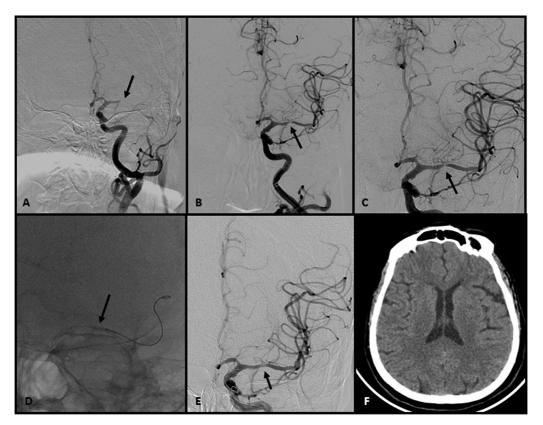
A 73 years old female who is a known hypertensive presented with right hemiplegia and aphasia for 6.5 hours with National Institutes of Health Stroke Scale (NIHSS) of 20. Imaging showed left M1 middle cerebral artery (MCA) occlusion with diffusion-weighted imaging (DWI) Alberta Stroke Program Early Computed Tomography Score (ASPECTS) of 8. (A) (arrow) Left M1 MCA occlusion for which underwent mechanical thrombectomy using modified Solumbra technique achieving modified Thrombolysis in Cerebral Infarction (mTICI) 3 recanalization with significant residual stenosis (90%) (arrow, B). Intra-arterial tirofiban was administered using a microcatheter to prevent reocclusion (arrow, C). Because of significant residual stenosis due to underlying intracranial atherosclerotic disease (ICAD), submaximal angioplasty of the stenosis of left M1 MCA was done (D), achieving good luminal caliber and mTICI 3 reperfusion (arrow, E). Twenty-four hours' follow-up computed tomography (CT) showing no evidence of hemorrhage. (F). The patient was functionally independent with a modified Rankin Scale (mRS) score of 0 at 3 months' follow-up.
